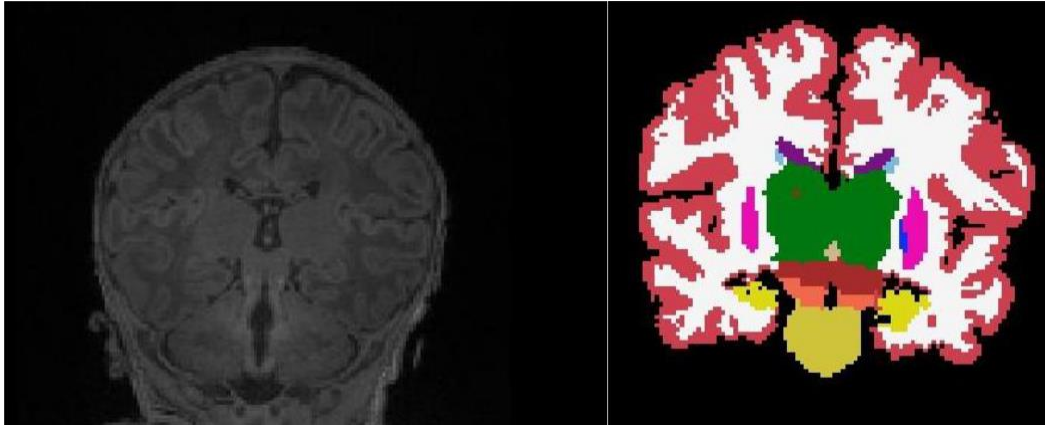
Coronal view of T1-weighted Infant MRI before and after volumetric segmentation
